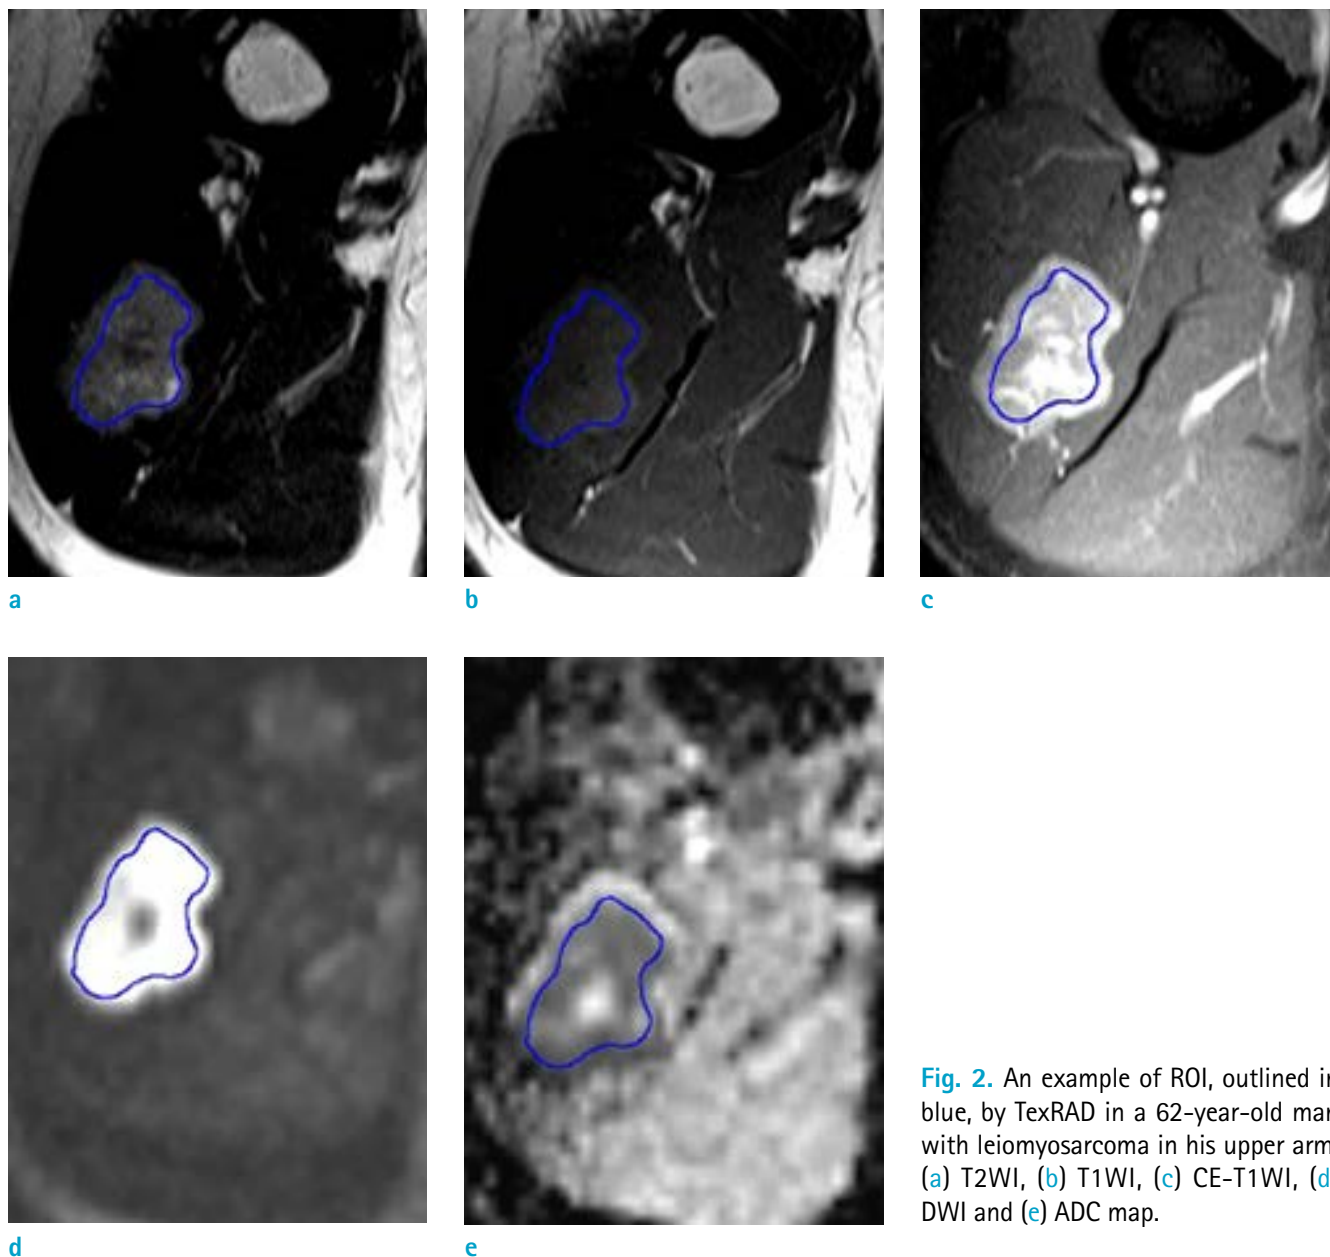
An example of ROI, outlined in blue, by TexRAD in a 62-year-old man with leiomyosarcoma in his upper arm. (a) T2WI, (b) T1WI, (c) CE-T1WI, (d) DWI and (e) ADC map.
